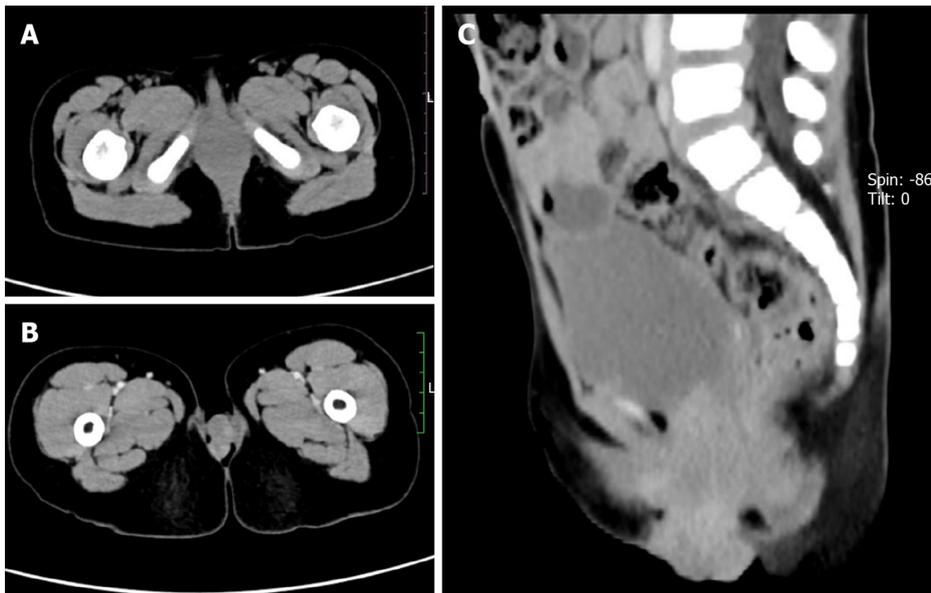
Computed tomography evaluation of Case 2. A: Axial computed tomography image showing an irregular soft tissue density in the vagina; B: Enhanced image showing non-uniform lesion enhancement; C: Sagittal image showing partial lesion protruding into the vagina.
